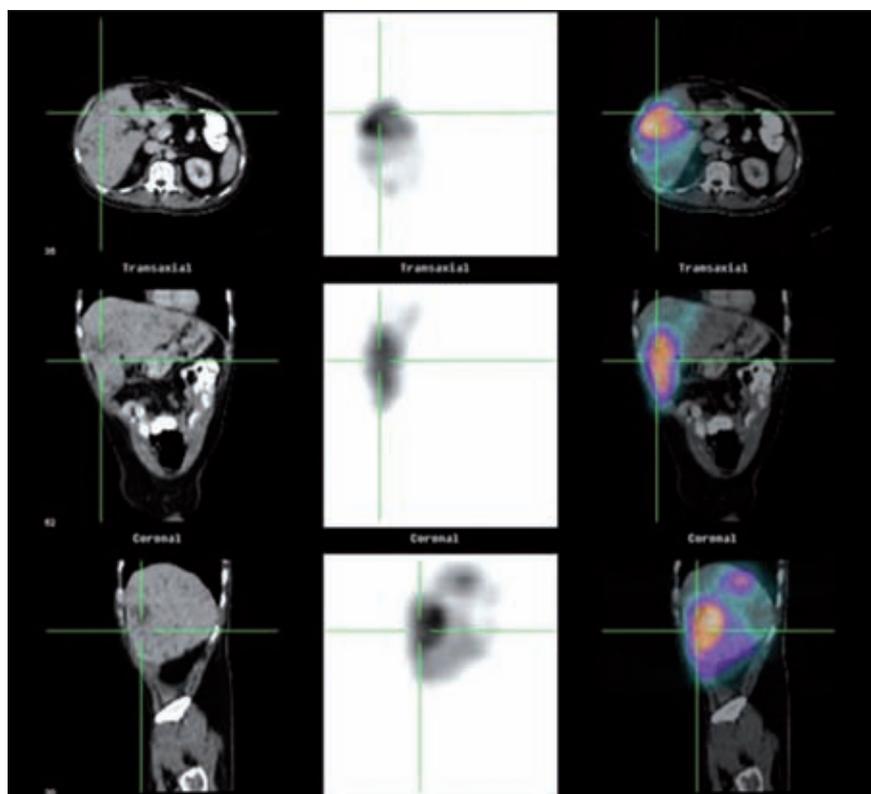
SPECT-CT fusion images showing the distribution of the Tc-99m-MAA in concordance to CT images which were obtained for PET-CT study.
